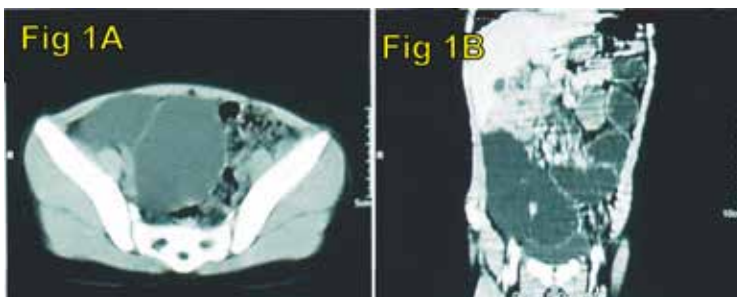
Computed tomography images in (A) Transverse & (B) Saggital plain showing a large hypodense non-enhancing cystic lesion extending from inferior aspect of right hepatic lobe to pelvis. The cyst is thin walled with few incomplete septae.
